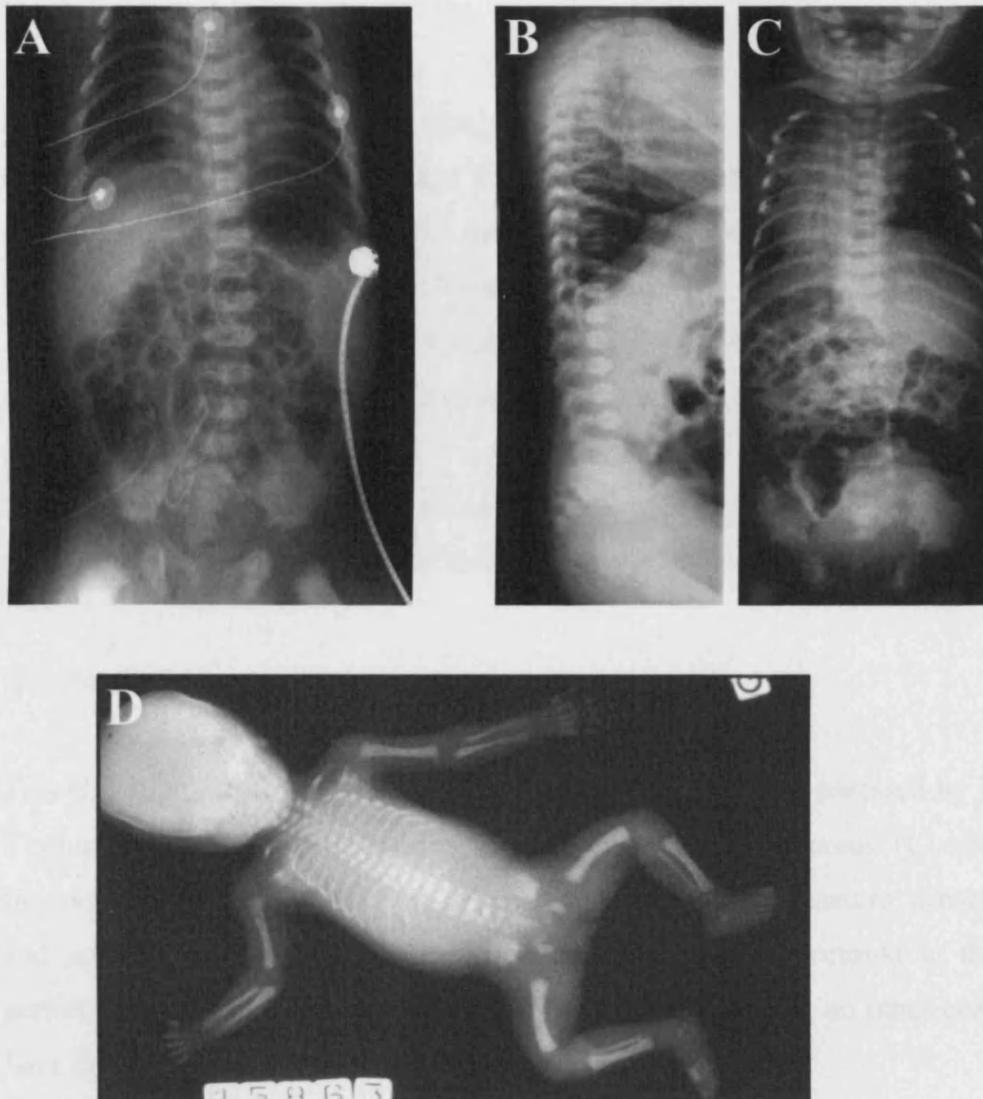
Radiographs of patients II.10 (A), II.1 (B and C) and fetus II.9 (D) from Family 10 showing the typical skeletal abnormalities of JATD. They have narrow thoraces with short ribs and the acetabulae have a trident appearance.
